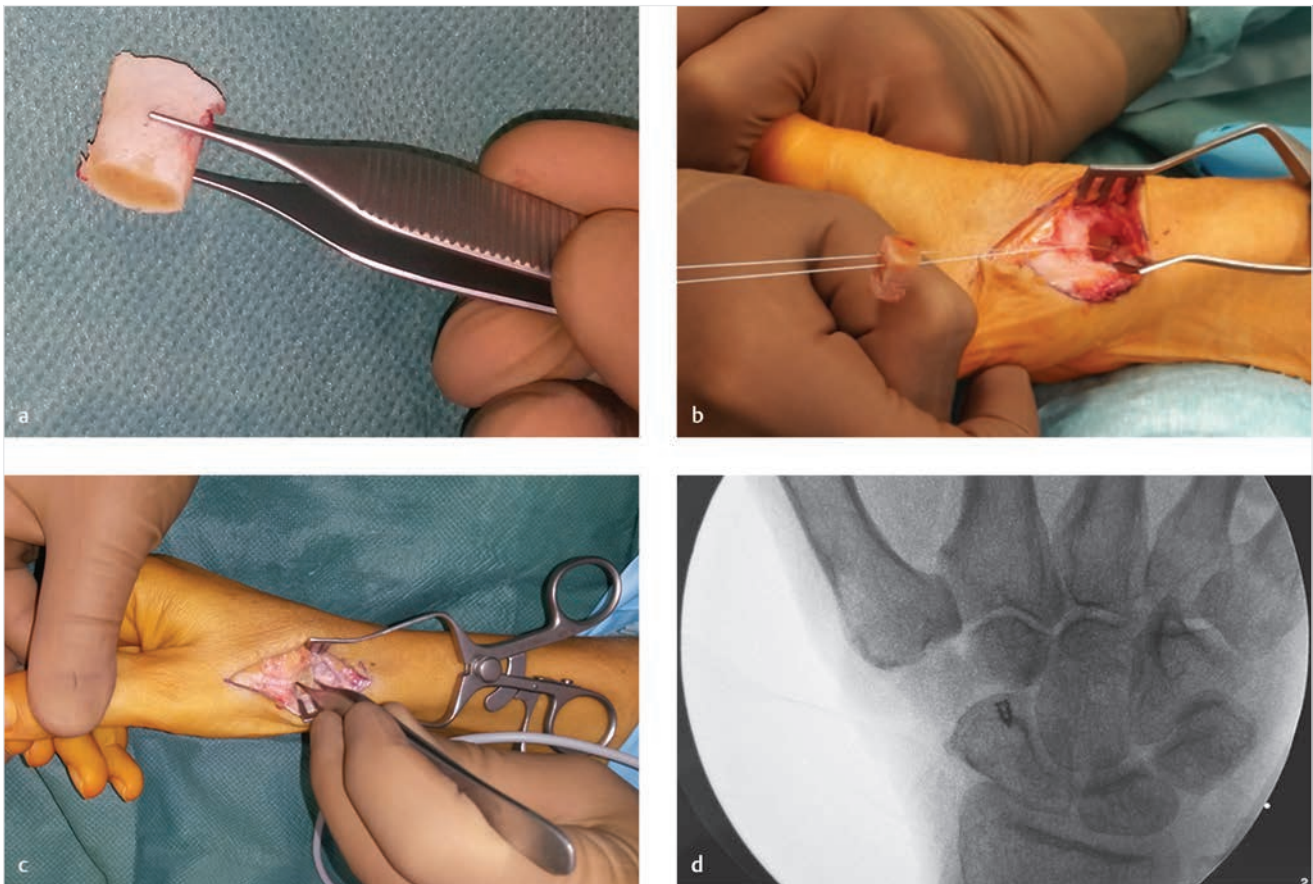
(a) The rib cartilage graft. (b) Suture anchor in the distal scaphoid with the graft threaded. (c) Graft in the trapezial space between the branches of the forceps. (d) X-ray during surgery suture anchor and graft in place.
